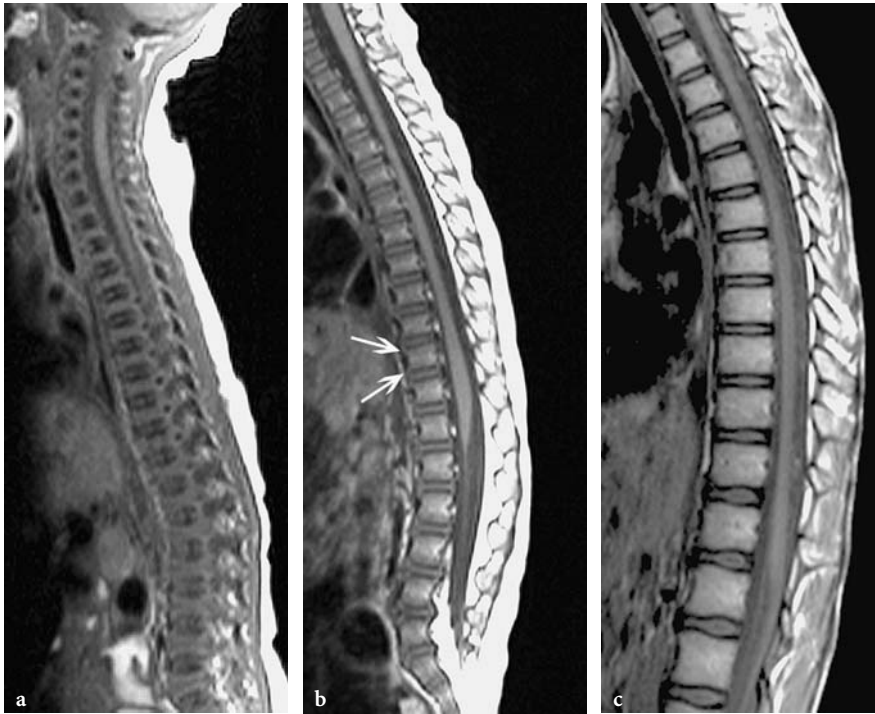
Sagittal T1-weighted SE images in a neonate (a), a 1-year-old boy (b) and a 14-year-old girl (c). Note the predominantly hematopoietic red marrow in the newborn (a) and the progressive conversion to yellow marrow (b,c). In the 1-year-old boy red marrow is seen at the endplates (b, *arrows*)
